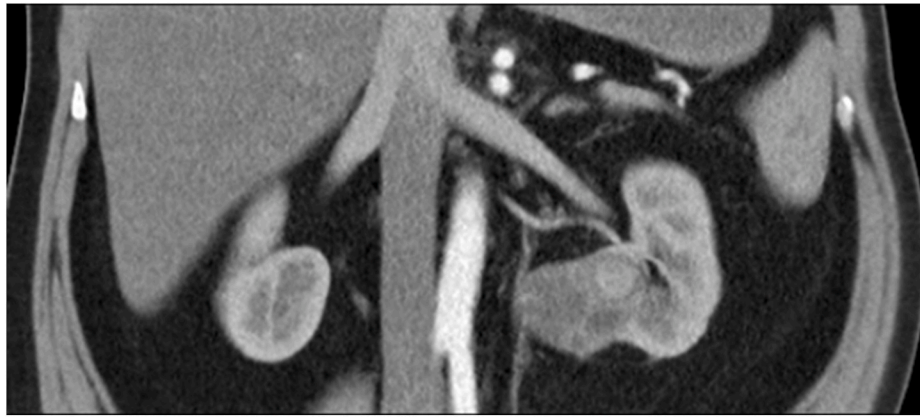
Coronal section of a contrast-enhanced CT image showing a mass in the lower pole of the left kidney.
